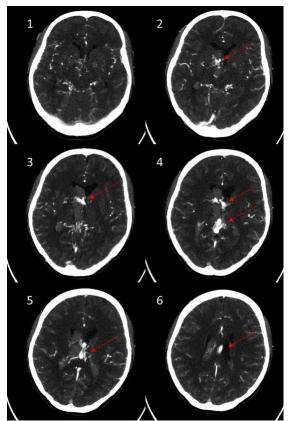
CTA arterial contrast phase; the nidus of AVM is pointed by red arrows
